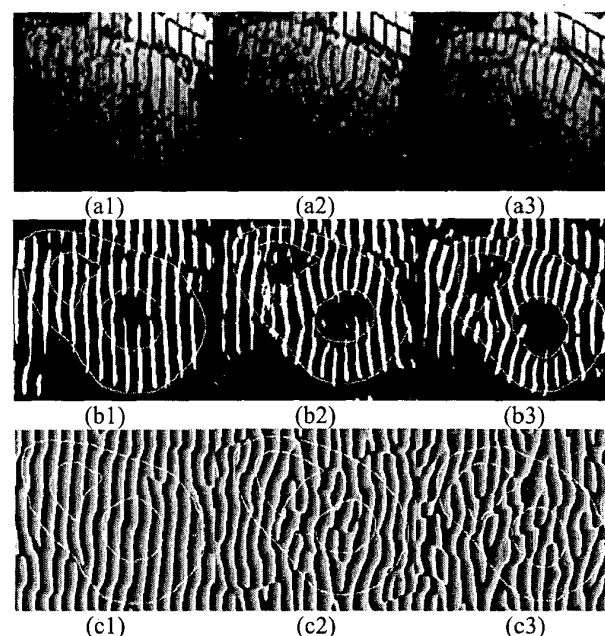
(a) Three tagged cardiac MR images in short axis. They are taken from a MRI sequence during systole. (b) The output results of our method. (c) HARP's result. The myocardium contours are drawn manually for better readability.
